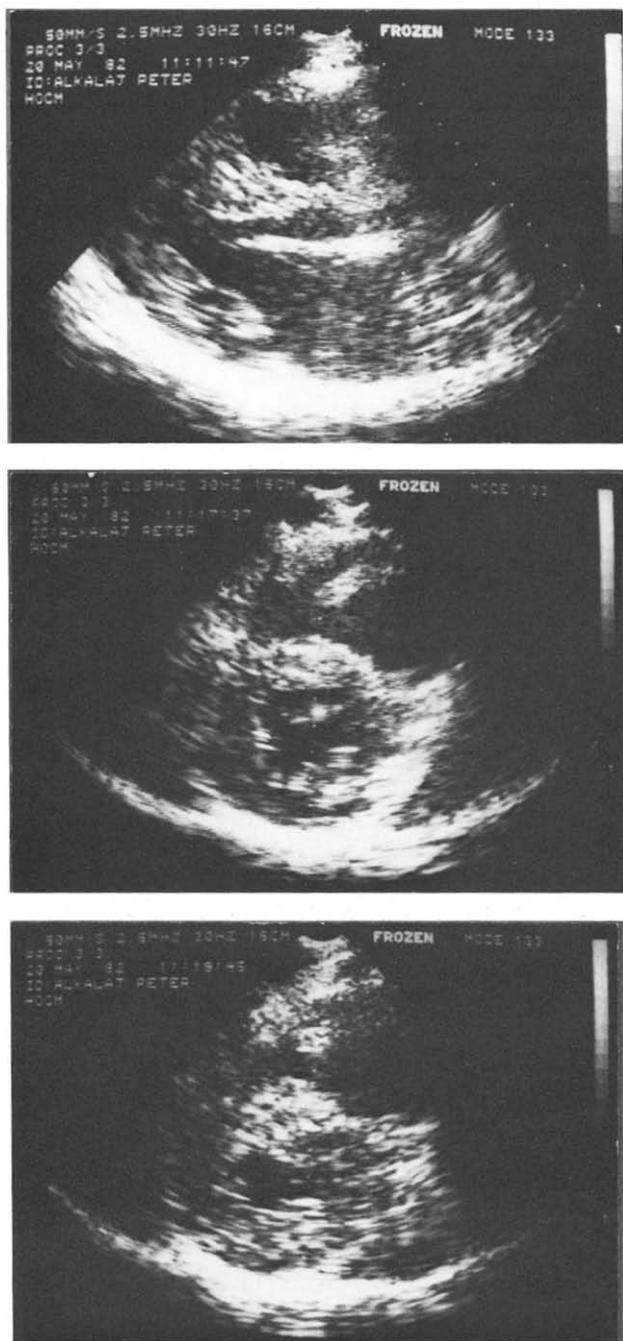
Parasternal long-axis (top) and short-axis (middle and bottom) view of a patient with distal ventricular hypertrophy. The upper ventricular wall thickness in the portion sampled by the M-mode beams is relatively normal (top and middle), but there is gross distal ventricular hypertrophy (bottom).
